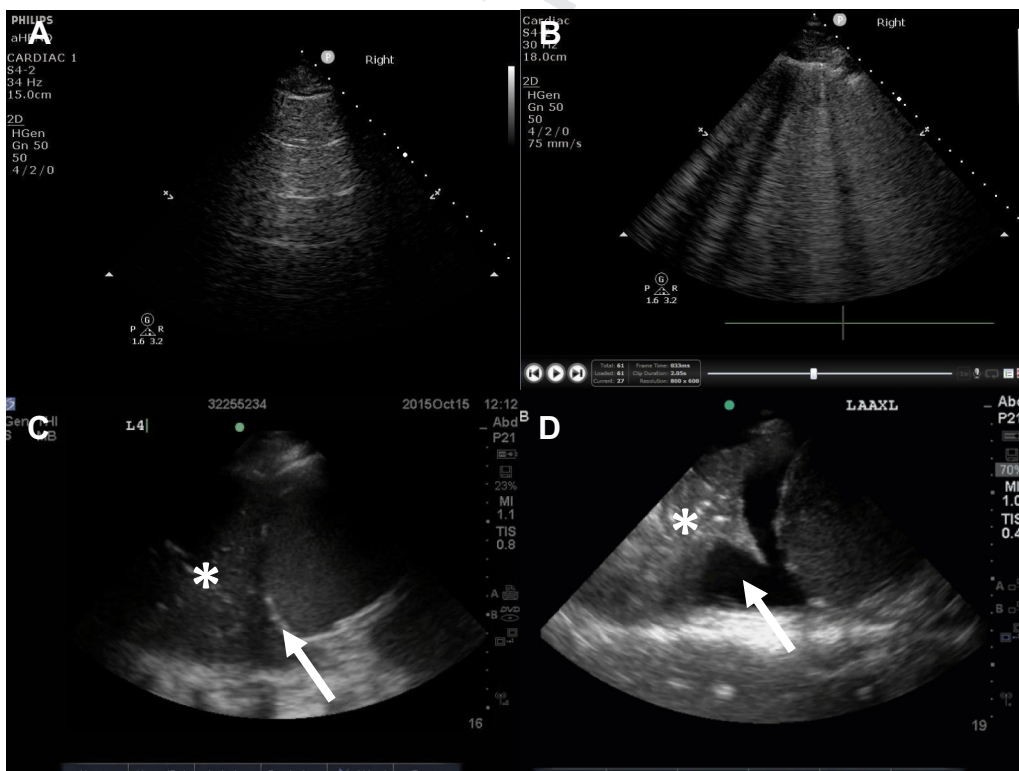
A-D, Thoracic ultrasound for lung congestion. A, Typical A-lines, here generated with the phased-array transducer oriented perpendicular to the rib and placed at the level of the second intercostal space in the mi-clavicular line. B, Typical B-lines; here the transducer is in the same position but oriented parallel to the ribs. C, Lung consolidation (asterisk) above the diaphragm (arrow). D, Pleural effusion (arrow) with associated consolidated lung (asterisk).
